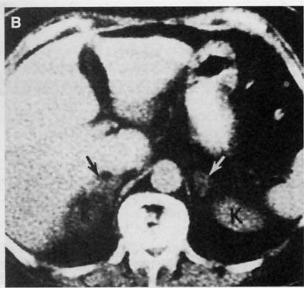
(A) CT scan of a patient with Cushing syndrome caused by an adrenal adenoma. A large mass (arrows) is seen in the left adrenal gland, posterior to the pancreas and anterior to the kidney (K). The normal right adrenal gland is shown (arrowhead). An adrenal adenoma usually occurs unilaterally, whereas adrenal hyperplasia occurs bilaterally. (B) CT scan of a patient with Cushing syndrome caused by adrenal hyperplasia. Both adrenal glands (arrows) are enlarged, but they retain their normal anatomic shapes. The normal appearance of the adrenal glands, except for the increased size, may confound the diagnosis. In some cases of adrenal hyperplasia, the adrenal glands show bilateral nodularity. [Reprinted with permission from Weyman PJ, Glazer HS: Adrenals. In Lee JKT, Sagel SS, Stanley RS (eds): Computed Body Tomography. New York, Raven Press, 1983.]
